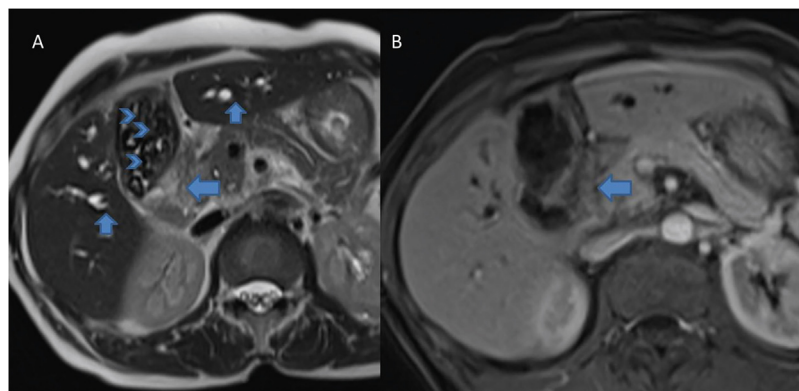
Axial T2 weighted (A) and gadolinium enhanced (B) MR images show soft tissue mass at the neck of the GB (arrows, A and B). Also note bilateral IHBRD (short arrows, A) and cholelithiasis (arrow head, A).
